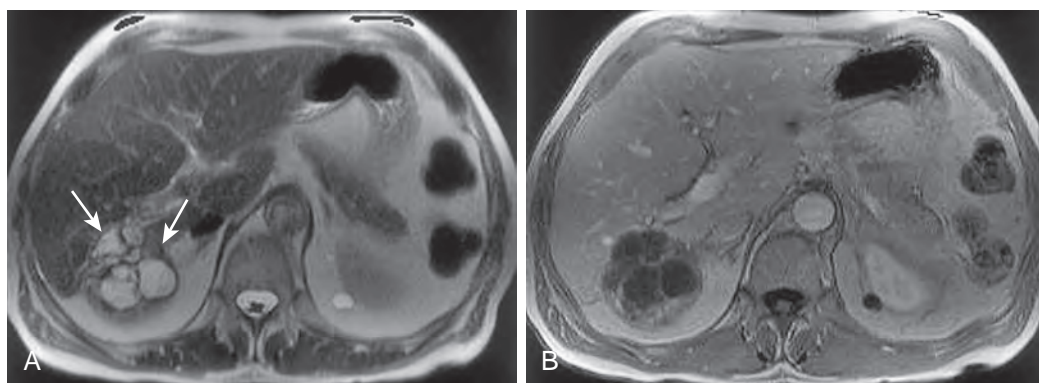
Biliary cystadenoma on MRI. A. Fast spin-echo T2-weighted MR image shows a multilocular, septated mass (arrows) in segment VII of the liver, with high signal intensity within the tumor. B. Corresponding portal venous phase gadolinium-enhanced T1-weighted image shows enhancement of the capsule and septa. (From Mortelet KJ, Ros PR: Cystic focal liver lesions in the adult: Differential CT and MR imaging features. *RadioGraphics* 21:895–910, 2001.)
